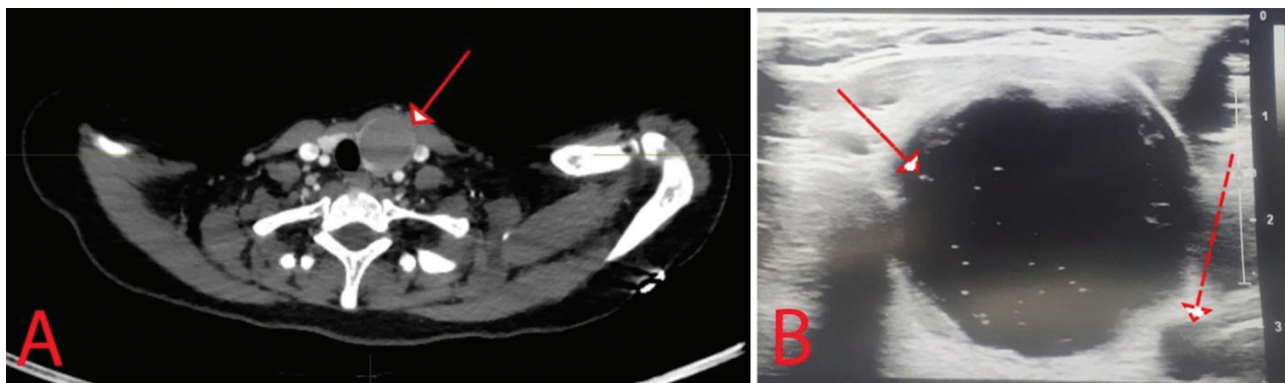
Imaging of the thyroid gland. A. CT of the thyroid (axial section, arrow indicates the cyst with hemorrhagic component); B. USG of the thyroid cyst (arrow indicates the “comet tail” sign; dashed arrow indicates the carotid artery).
